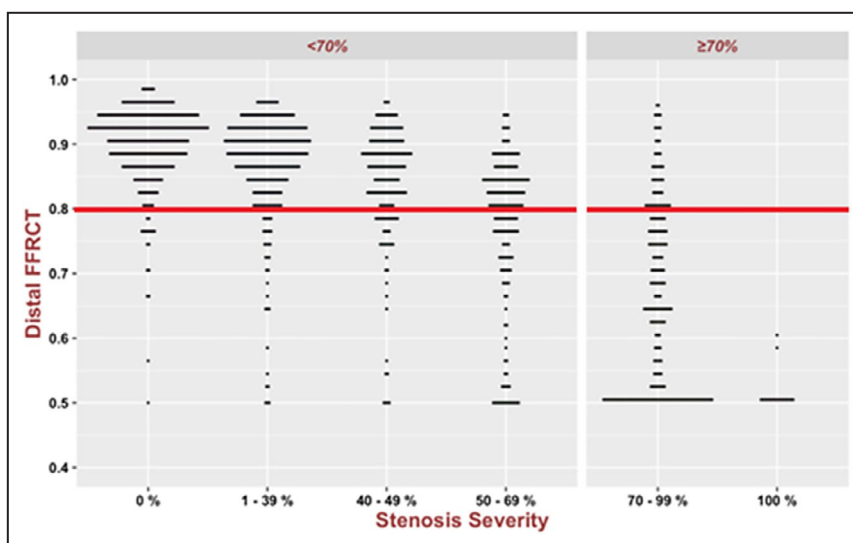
Line plot of distal FFR_{CT} by stenosis severity category (n=1245 vessels). The horizontal red line represents the cut-off point of FFR_{CT} for significant flow impairment (≤0.80). FFR_{CT} indicates fractional flow reserve derived from computed tomography.
